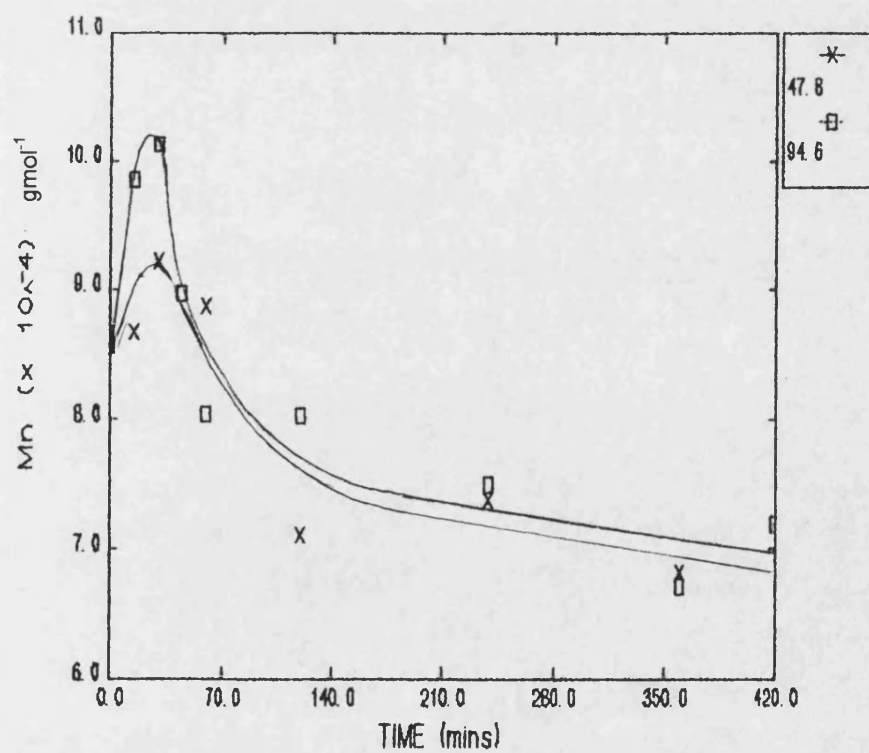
Effect of varying ultrasonic intensity upon  $M_n$  for a 5% (w/v) solution
